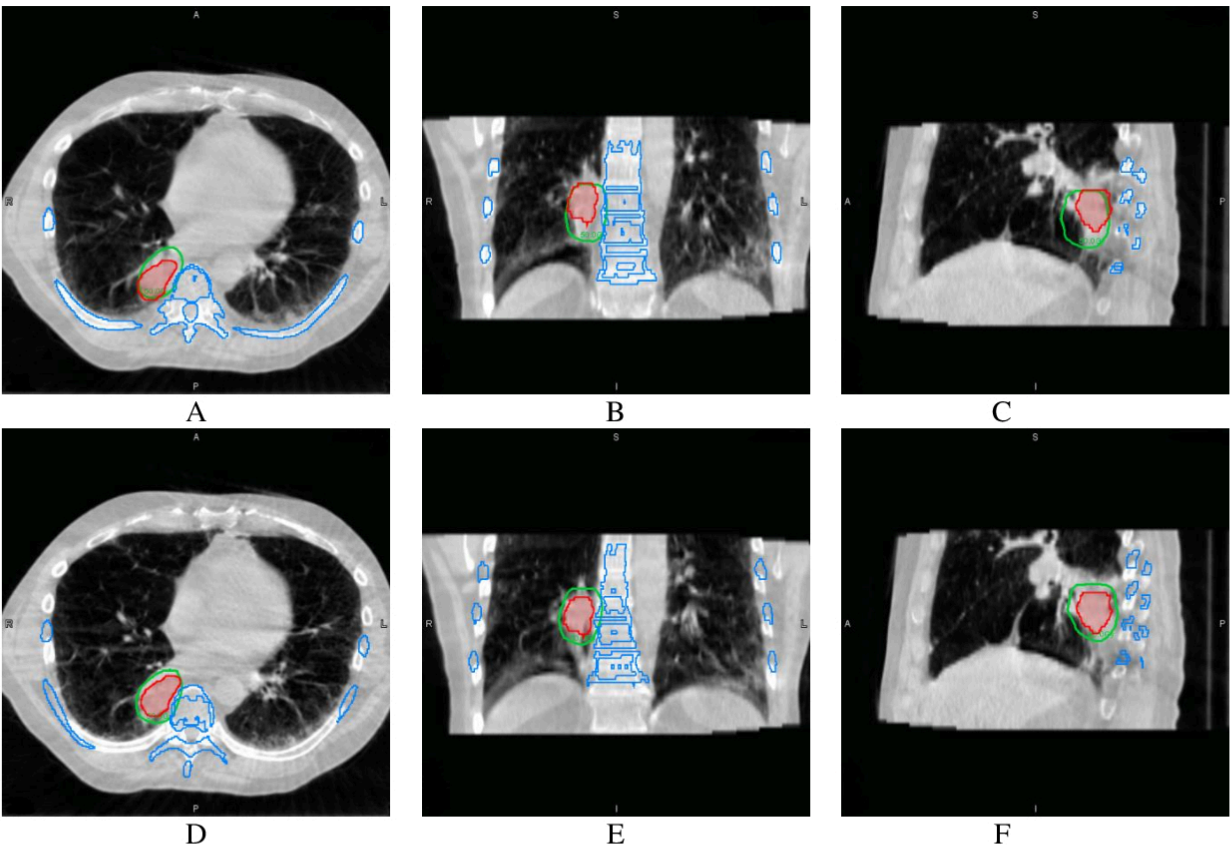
Case demonstration. ITV was indicated by the shaded red area, the bony structure contoured on the planning CT after the image registration was represented in blue, and the prescription isodose line was circled by the hollow green area. Bone-to-bone alignment was presented on the top row (figure A to C), in which the ITV was not completely covered by the prescription isodose line. In contrast, tumor-to-tumor alignment presented on the bottom row (figure D to F) demonstrated that the prescription dose covered the ITV
